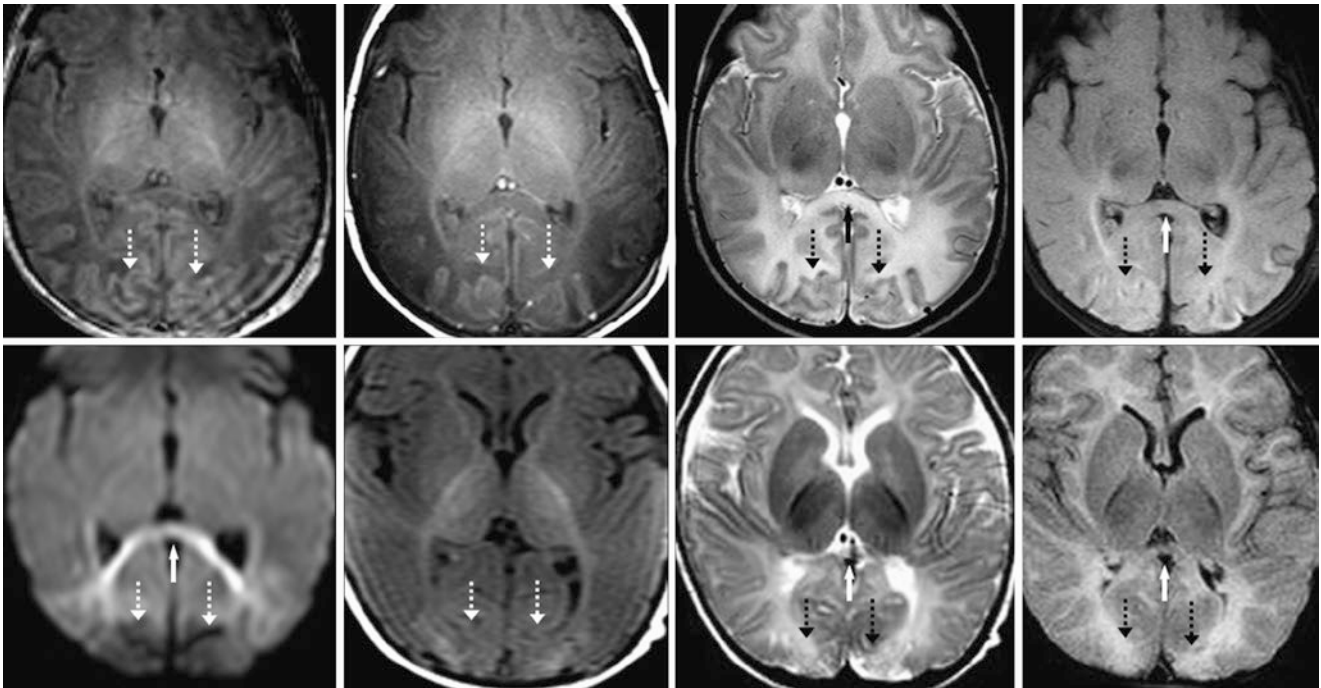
Comparison case of mild HII. An 8-day-old term neonate with birth asphyxia. *Top row:* On 3T MRI, the basal ganglia, PLIC, and VLT were normal on GE T1WI (*left*) and SE T1WI (*left middle*); SE T2WI (*right middle*) and FLAIR (*right*) both showed subtle edema within the callosal splenium (*arrows*) and occipital cortices (*dotted*
